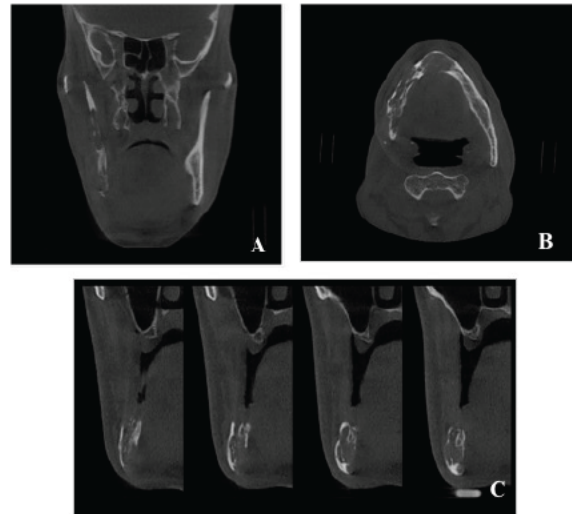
CBCT images of the lesion – A: Coronal image demonstrating perforations of the medial and lateral aspect of the ramus without expansion. B: Axial image shows perforation of the buccal and lingual plates without significant expansion. C: Cross sectional images shows the cortical borders of the inferior alveolar nerve canal remained intact, mouth eaten appearance of lesion can be seen.
